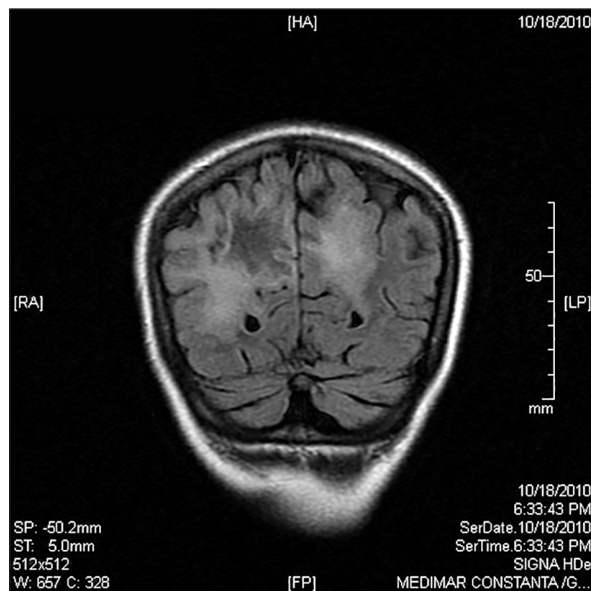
Cerebral MRI scan – the lesions appear hyperintense on T2 weighted images, with surrounding edema but without mass effect
